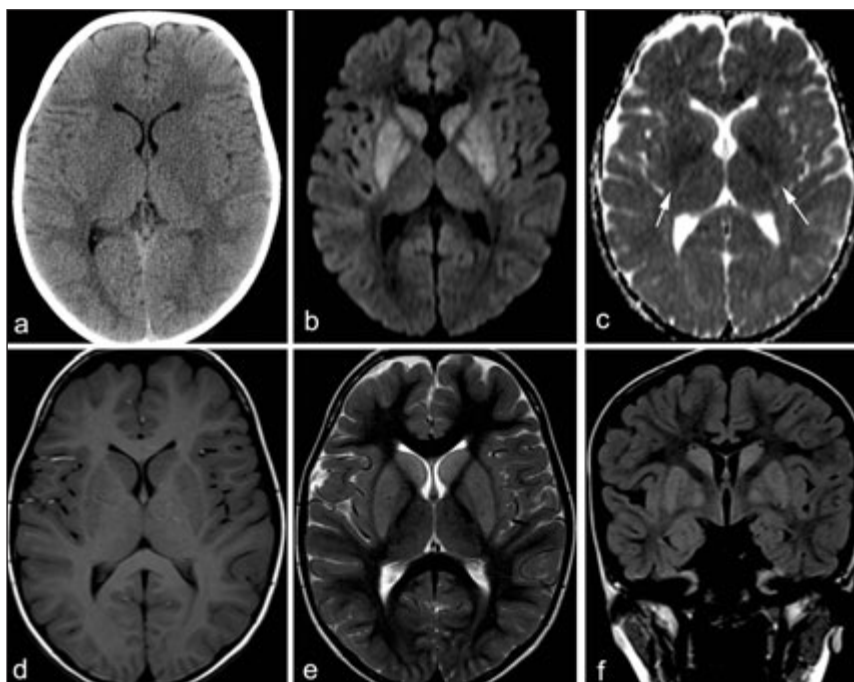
Non-contrast CT scan at presentation (a) shows hypodensity of bilateral caudate nuclei, putamina, and globi pallidi. Diffusion-weighted image (DWI) (b) one day after initial CT shows hyperintense signal in bilateral globi pallidi, putamina, and caudate nuclei. Apparent diffusion coefficient (ADC) map (c) shows slightly decreased signal in bilateral globi pallidi and putamina (arrows). T1-weighted MRI (T1-MRI) (d) does not show obvious abnormality. Slightly increased signal is seen in bilateral globi pallidi, putamina, and caudate nuclei on both T2-weighted (T2-MRI) (e) and fluid attenuated inversion recovery (FLAIR) (f) images.
